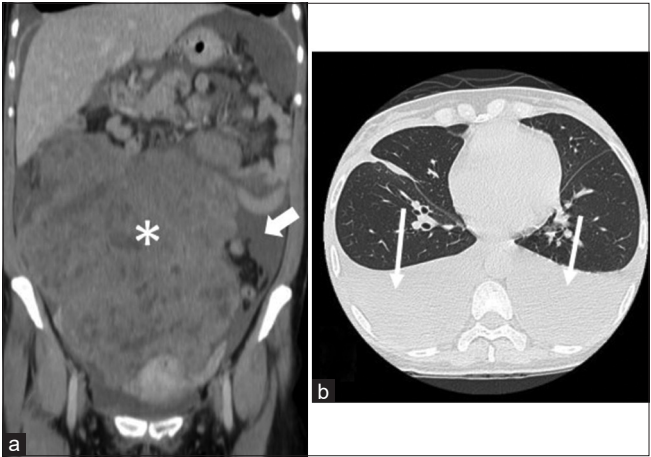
Abdominopelvic computed tomography demonstrated a huge ovarian tumor with an irregular surface (*) and ascites (arrowhead) (a) Chest tomography revealed bilateral pleural effusion (b)
